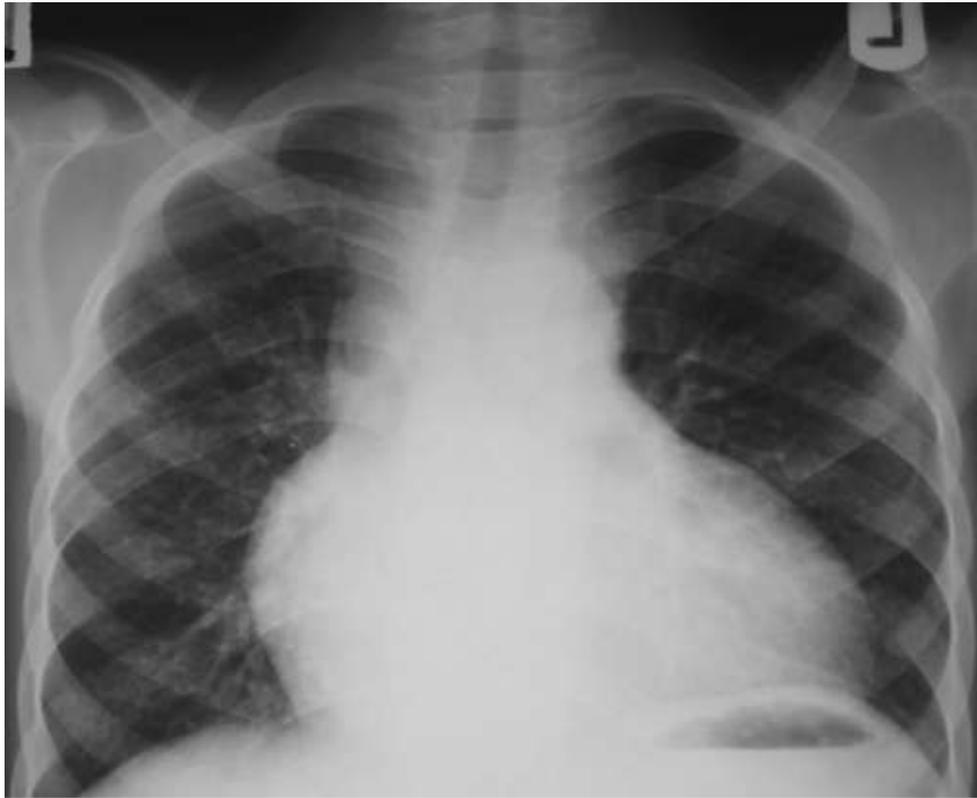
Fig I The chest radiograph showing cardiomegaly with concave pulmonary bay
